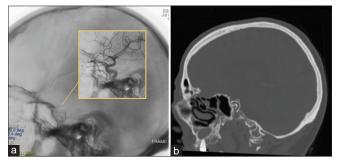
Intraoperative angiographic capture in lateral projection (a) shows the correct flow-diverter stent placement (Derivo©) within the right internal carotid artery (ICA), and subsequently angiographic elimination of the fistulous link and preserved patency of the vessels (ICA, ophthalmic artery) without complications (enlarged in the yellow box). In (b) sagittal bone-window head computed tomography scan a view of the implanted stent.
